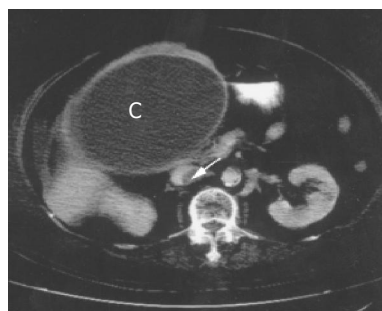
First CT scan shows that huge hepatic cyst (C) exhibits mass compression effect on IVC with thrombosis (arrow).
